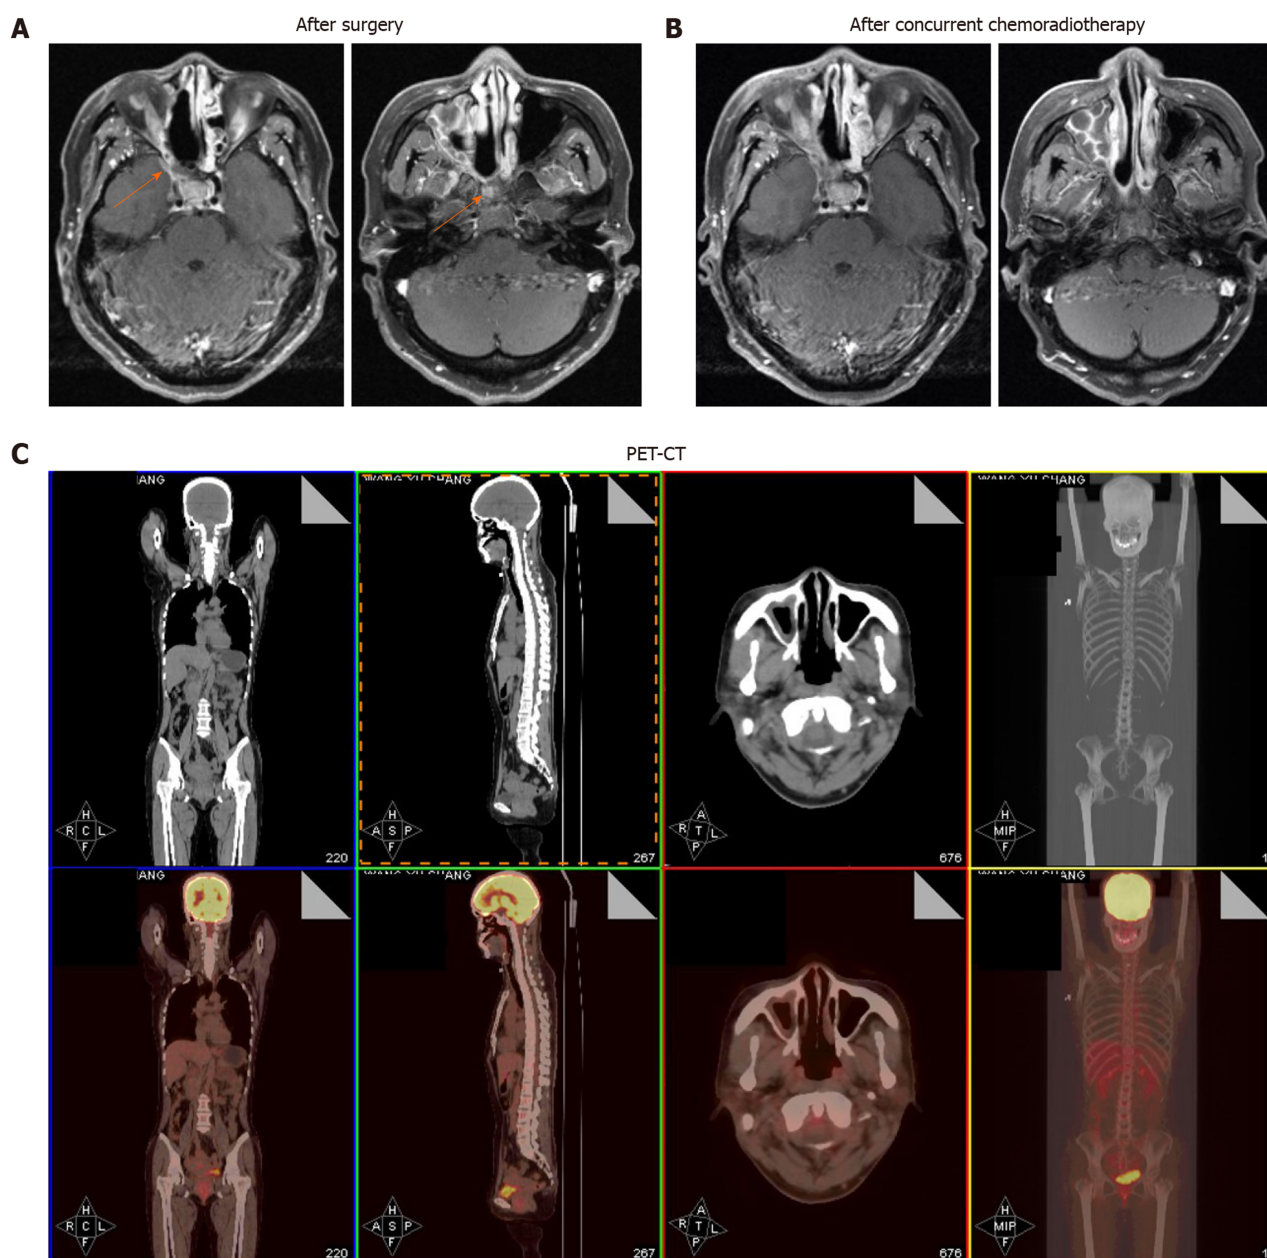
The patient has a complete response after chemoradiotherapy. A: Images after surgery showing postoperative residual lesions (orange arrows); B: Images after surgery showing that a complete response was achieved; C: The latest positron emission tomography-computed tomography showing no signs of recurrence or metastasis.
